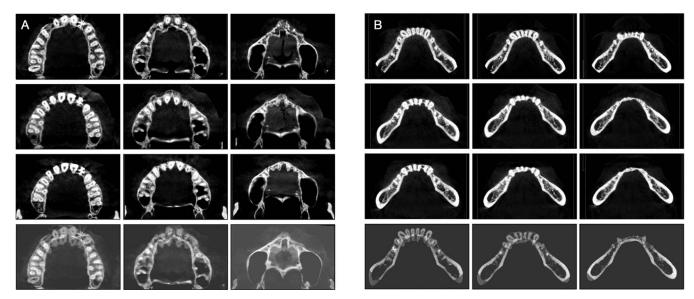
Despite the appearance of the (A) maxillary and (B) mandibular incisor roots outside the lingual cortical plate, the continuity of the lingual cortical plate remains clear. Axial sections of pretreatment (first row), posttreatment (second row), and follow-up CBCT were taken at the following levels: CEJ level (left column), 5-mm above CEJ (middle column), and 10-mm above CEJ (right column). Superimposition of pretreatment and posttreatment CBCT images show the extent of root movement (bottom row). CEJ indicates cemento-enamel junction.
